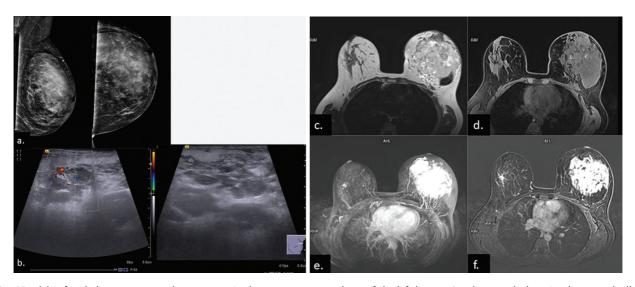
(a) Left sided mammogram shows a mass in the upper outer quadrant of the left breast. On ultrasound, there is a large markedly hyperechoic lesion nearly occupying the whole of the upper and outer half of the breast with multiple ill-defined variable sized hypoechoic nodular and tubular areas (b) Which show internal vascularity. (c) T2 MRI sequence reveals marked T2 hyperintensity within the mass. (d) T1 weighted sequence shows hypointense mass. (e and f.) Contrast-enhanced sequence shows intense enhancement in the mass. Biopsy confirmed the diagnosis of angiosarcoma. BIRADS, Breast Imaging and Reporting Data System; MRI, magnetic resonance imaging.
